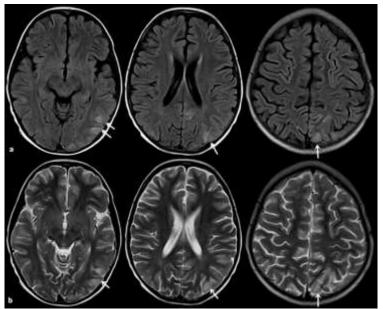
MRI achieved 4 hours after beginning of symptomis revealing areas of patchy high signal intensity lesions on FLAIR (a) and T2 weighted (b)axial slices, involving subcortical white matter and gray matter along with sulcus in left parietal-occipital regions (arrows). Enlargement of affected gyrus and neighboring sulcus effacement is also seen due to edema
